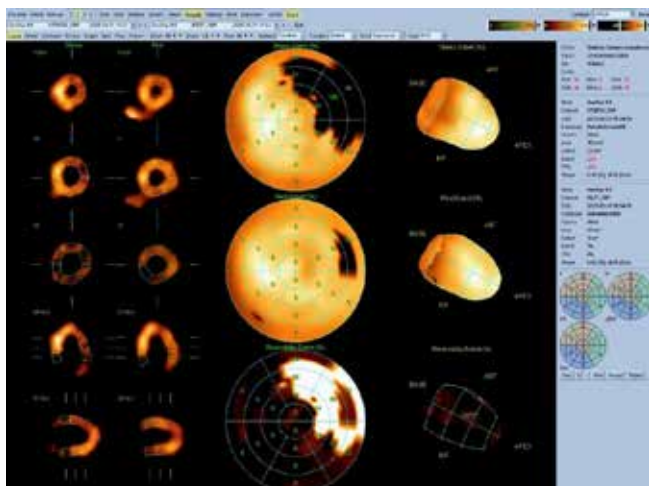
Myocardial scintigraphy
